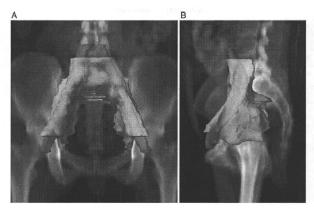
Digitally reconstructed radiographs showing CTV for pelvic lymph nodes (yellow) and vessels (orange); (A) anterior view and (B) lateral view.
